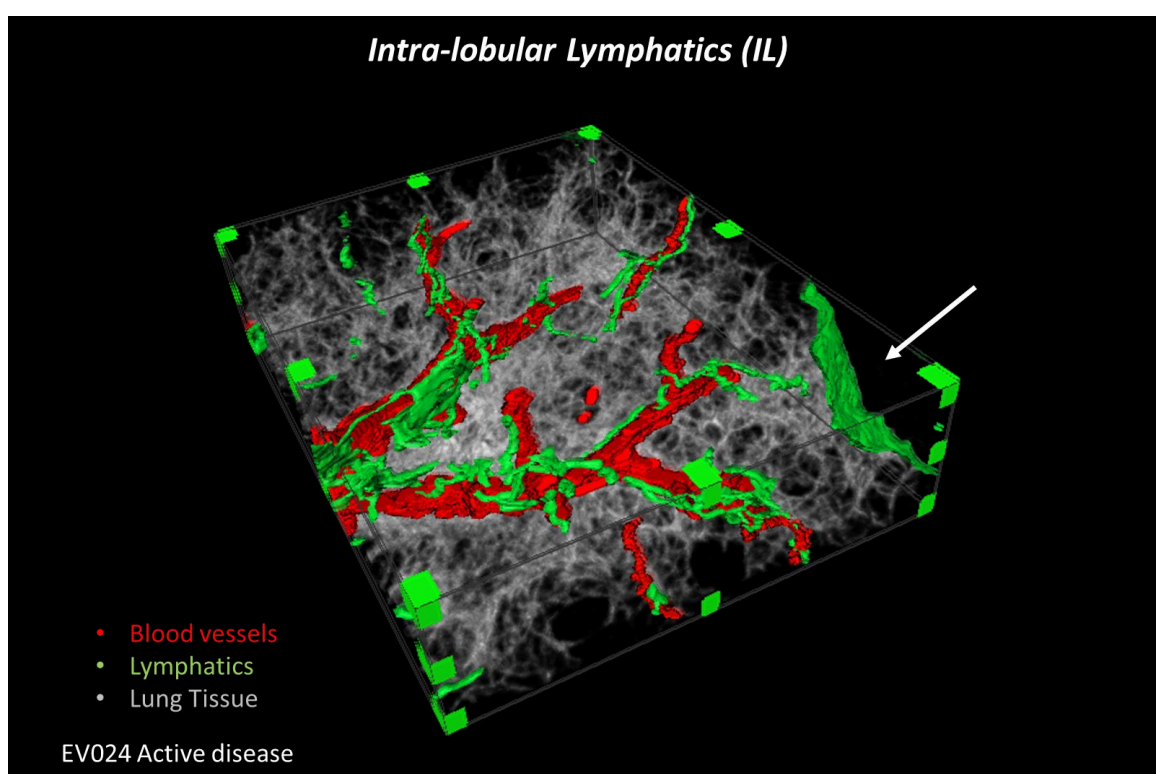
3D Volume Rendering of the Pulmonary Lymphatic Network in a Subvolume of Human Lung. The lymphatic vessel network is shown in green,  $\mu$ CT density map of the lung tissue is shown in grey. The areas which the VOIs are categorised by are labelled for this subvolume. The dimensions of the extent of this subsample are 9.7 mm; 7.5 mm; 0.5 mm in the green red and blue axes respectively.
